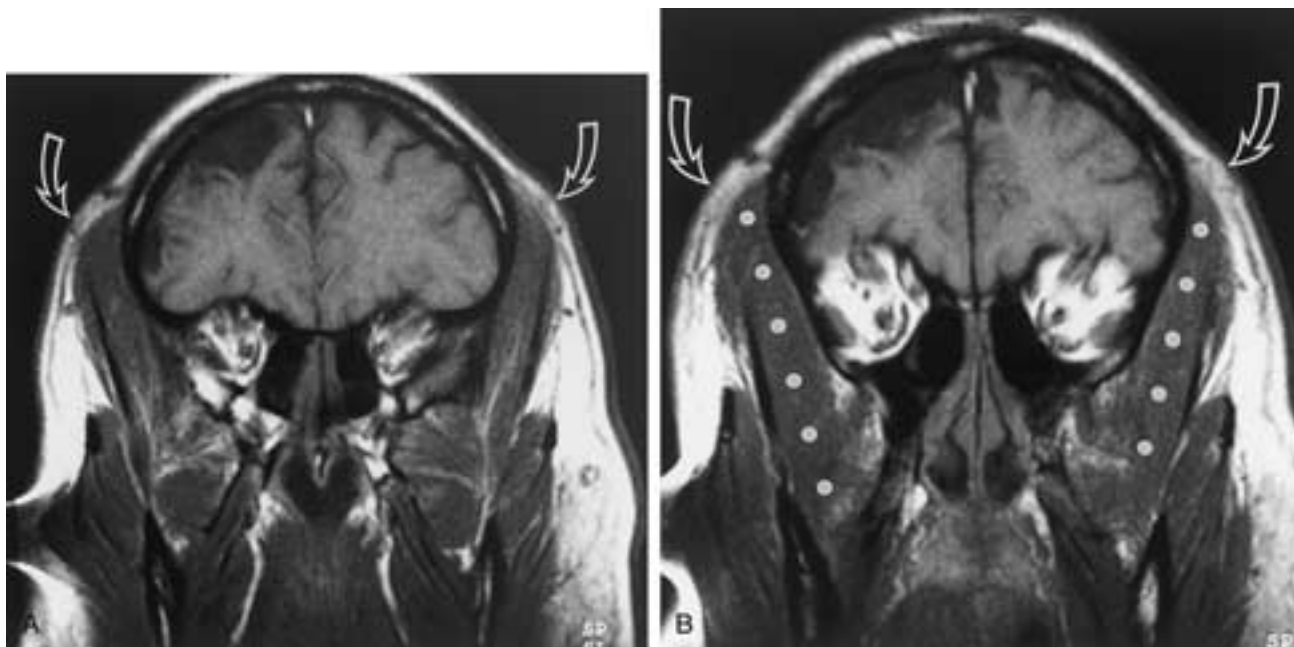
Hypertrophy of all muscles of mastication. A and B, Coronal T1-weighted MR images demonstrate marked enlargement of all muscles of mastication bilaterally. Note especially the temporalis muscle hypertrophy (dots in B) in the suprazygomatic masticator spaces, which causes the contour of the overlying scalp to bulge (arrows).
